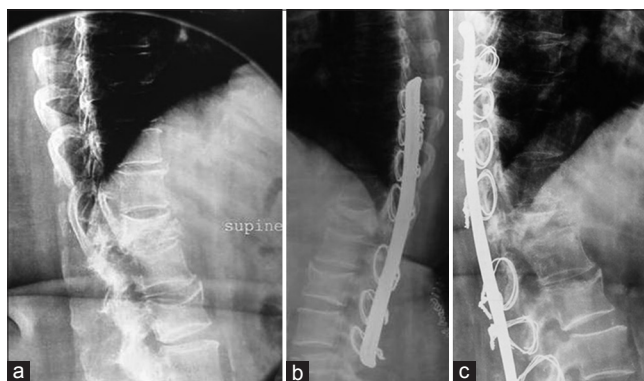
A 72-year-old female patient with osteoporotic vertebral compression fracture nonunion of the T12 vertebral body (a), immediate postoperative lateral view X-ray shows fracture stabilization with spinal loop rectangle and sublaminar wirings (b), postoperative follow-up X-ray at 2 years shows fracture healing by collapse with implants *in situ* (c)
